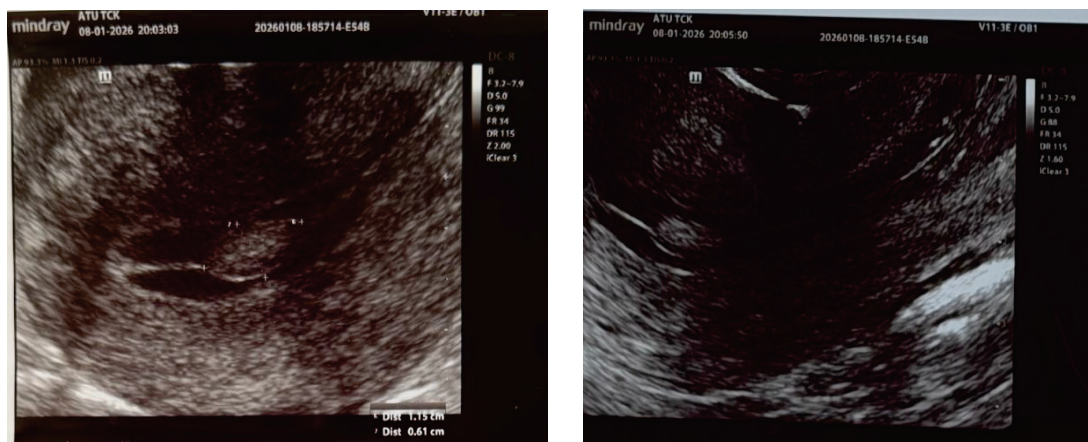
Transvaginal ultrasound. Ultrasound image of an endometrial polyp measuring 11.5×6.1 mm, visualized in the middle third of the uterine cavity from the anterior wall
